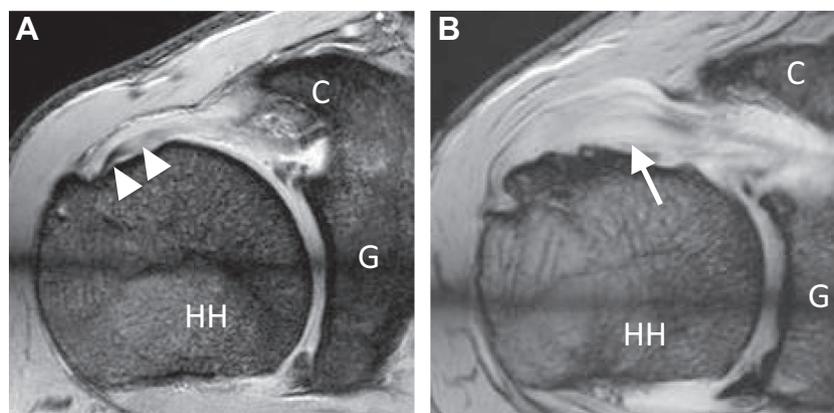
Representative case of normal or partial tears of LHBT in radial-slice MRI. (A) Clear finding in LHBT (*arrowheads*) showing negative findings. (B) Thickening of LHBT showing positive findings (*arrow*). C, coracoid; G, glenoid; HH, humeral head.
